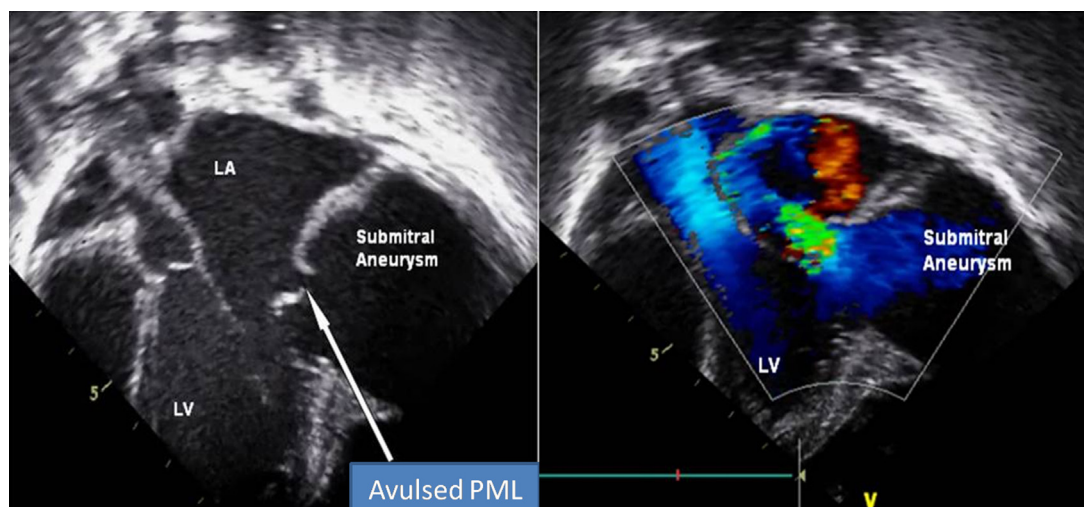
2D echocardiography and color Doppler images in apical views showing a large submitral aneurysm adjacent to posterior mitral leaflet with severe MR.
